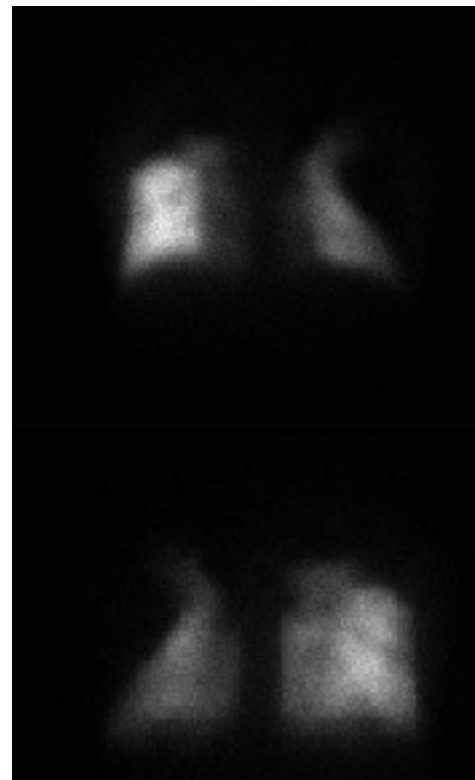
Perfusional scintigraphy bilateral bullae severe perfusion defect involving mainly the upper lobes
